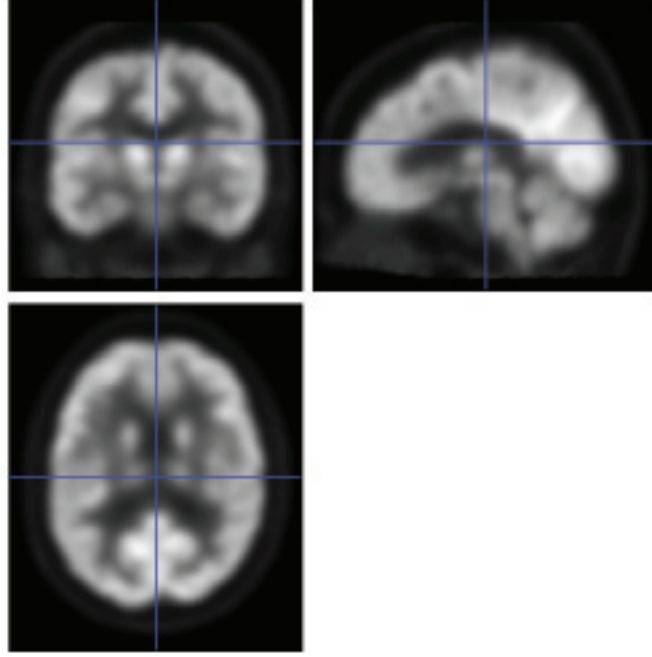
Example of result registration between PET and MRI using SPM12.
